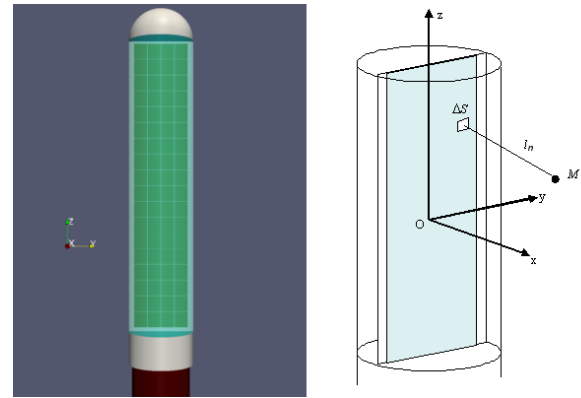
3D view of the 64 elements ultrasound therapy probe (left) [4]. Ultrasound probe geometry and coordinate system (right).
